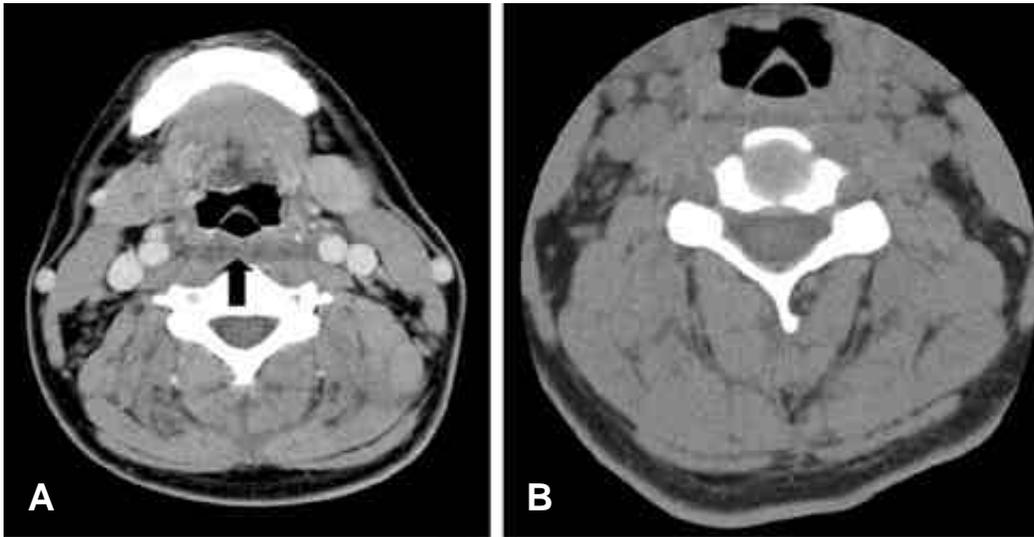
Axial computed tomography scans. It shows slightly low to intermediate density and widening of retropharyngeal space (black arrow) at HD#2 (A), and decreased widening of retropharyngeal soft tissue at HD#5 (B).
